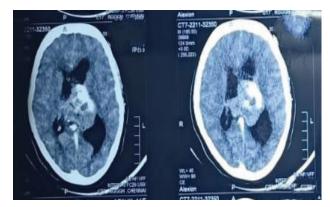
Contast CT brain showing contrast enhancing lesion in left lateral ventricle with extention into right lateral ventricle
